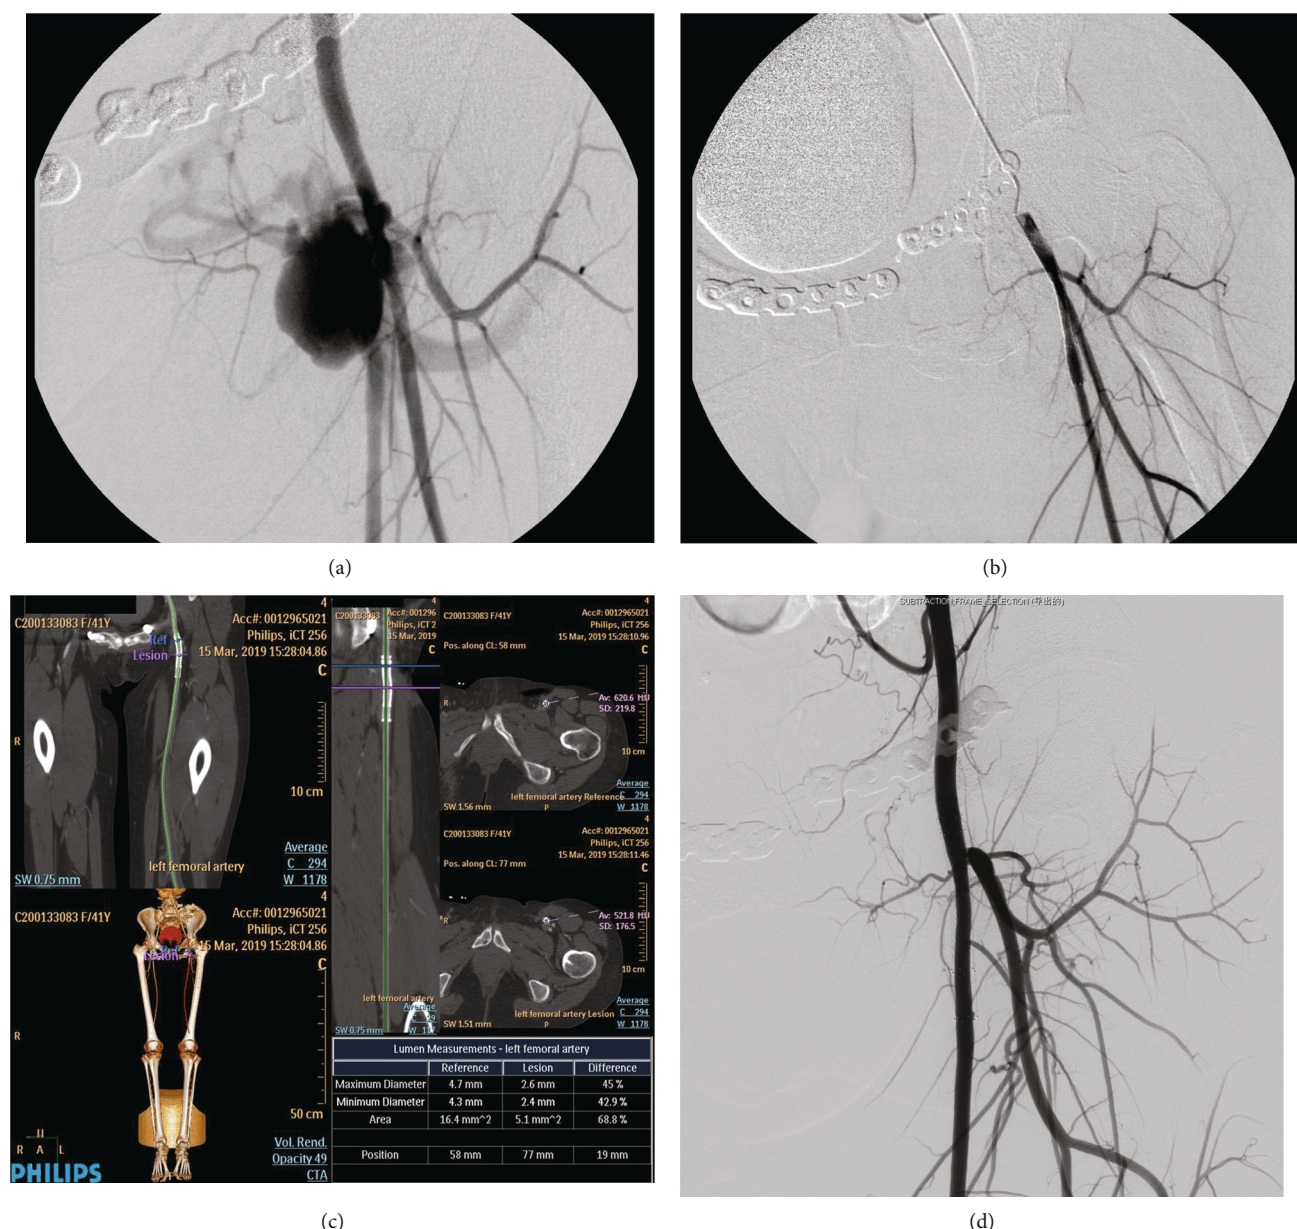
A pseudoaneurysm of the left superficial femoral artery due to a comminuted pelvic fracture. (a) DSA before the operation in March 2014 revealed a pseudoaneurysm at the root of the left superficial femoral artery with a  $2.9 \times 2.2$  cm of maximum diameter. (b) After double-layer bare stent placement, DSA showed that the hematoma cavity disappeared and no contrast extravasation. (c) CTA in Mar 2019 revealed that the blood flow in the stent lumen was smooth, and there was no stenosis in the lumen. (d) Angiography in May 2019 revealed that the blood flow in the stent lumen was smooth, and there was no stenosis in the lumen.
